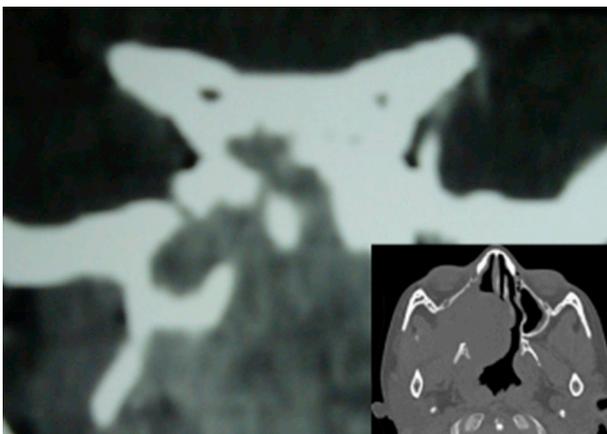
CT scan coronal and axial (inset) cuts (bone window) showing erosion of cancellous bone of pterygoid-base with involvement of vidian canal, posterior ethmoid/sphenoid sinuses and lateral extension as per Fig. 1.
